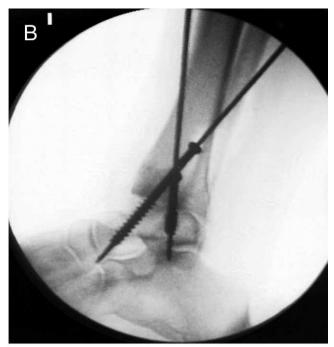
(*A*) Intraopertive photograph showing the placement of the posterior medial screw. It is aimed to purchase the talar head and should be contained within the talar neck. (*B*) Interoperative lateral radiograph showing the proper orientation of the first screw. (*C*) Immediate postoperative anteroposterior radiograph showing the screw threads completely in the substance of the talar head.
